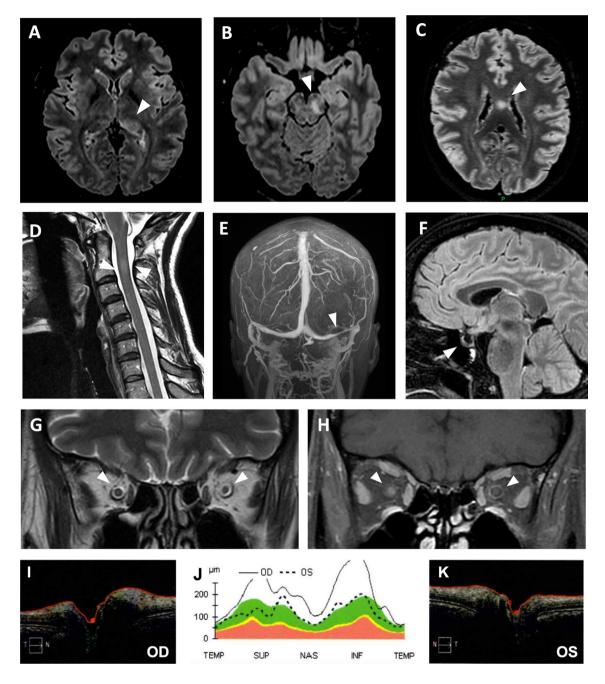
MRI and optical coherence tomography data. A–B Data from the first MRI showing white-matter FLAIR hyperintensities of the left posterior thalamus (panel A), left cerebral peduncle (panel B) (arrow heads). C–D Second MRI data showing white-matter FLAIR hyperintensities of the corpus callosum (panel C), and C2 myelitis (in T2-weighted images, panel D) (arrow heads). E–G Intracranial hypertension aspects with right lateral sinus stenosis (panel E), empty
